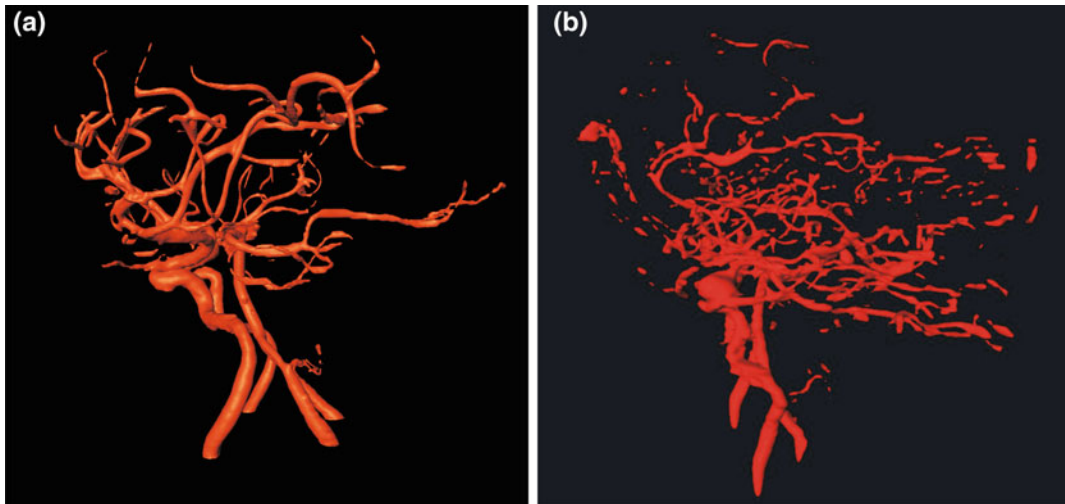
Examples of Magnetic Resonance Angiography (MRA) model and Computed Tomography Angiography (CTA) model of cerebral vasculature. The model on the left a was created from the Magnetic Resonance Angiography data; blood vessels appear smooth with no gaps.
